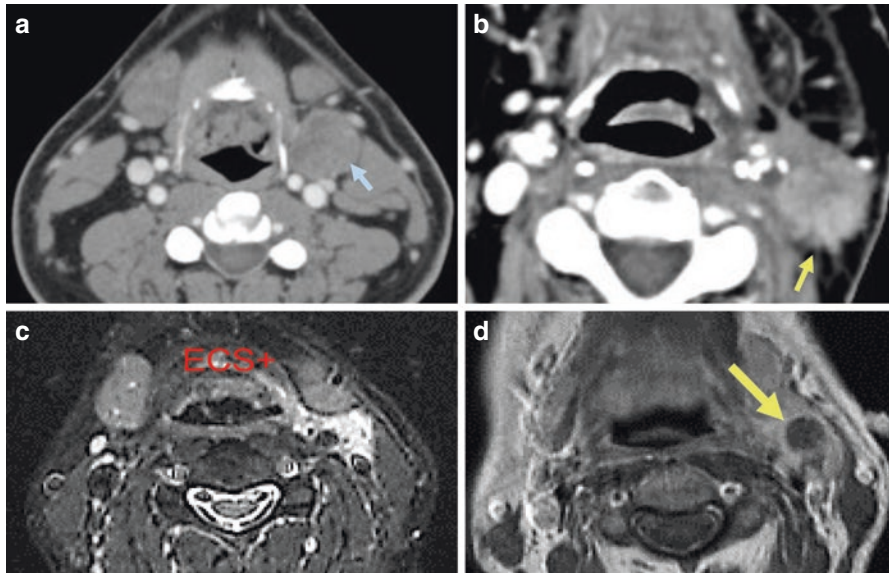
(a) Axial CT with contrast shows left Level II enlarged lymph node (arrow) with smooth wall contours with no surrounding infiltration. ECS negative. (b) Axial CT with contrast shows left Level II enlarged lymph node with irregular capsule with prominent spiculation (arrow) and surrounding infiltration. ECS positive. (c) MR axial STIR image shows irregular hyperintense level II lymph node with surrounding interstitial infiltration. ECS positive. (d) MR axial T1w image after contrast shows prominent central nodal necrosis (arrow) and wall contour irregularity and surrounding infiltration. ECS positive
